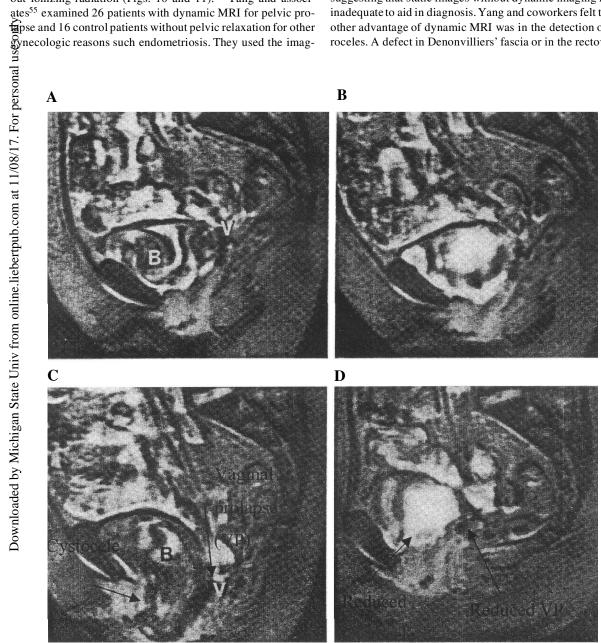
Sagittal dynamic MR images of postmenopausal woman with stress urinary incontinence. (A) Bladder (B) and vaginal (V) positions without strain. (B) Positions during mild strain. Note small cystocele and vaginal prolapse. (C) Positions during strong abdominal straining. Note pronounced cystocele and vaginal vault prolapse (VP). (D) Prolapsed organs are completely reduced. (Reprinted with permission from Yang A, Mostwin JL, Rosenshein NB, et al. Pelvic floor descent in women: Dynamic evaluation with fast MR imaging and cinematic display. Radiology 1991;179:25-33.)
